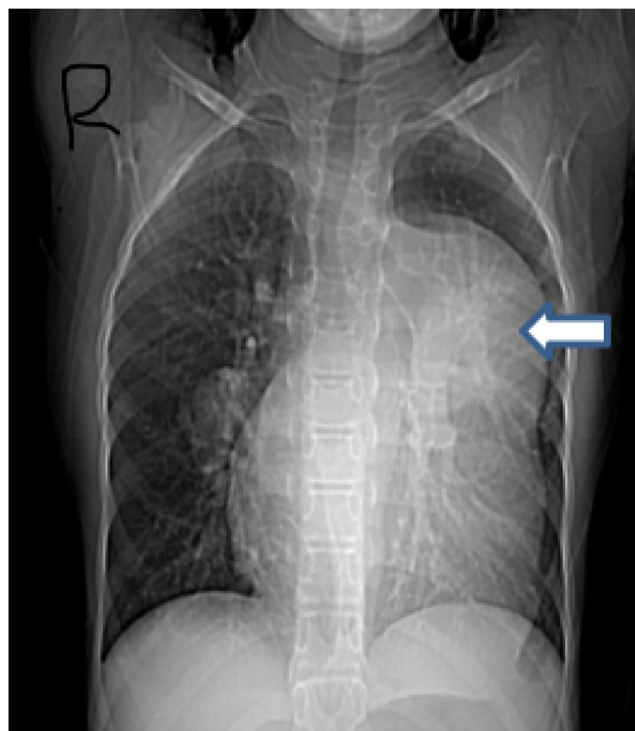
Frontal chest x-ray showing smooth left hilar radiopacity.
